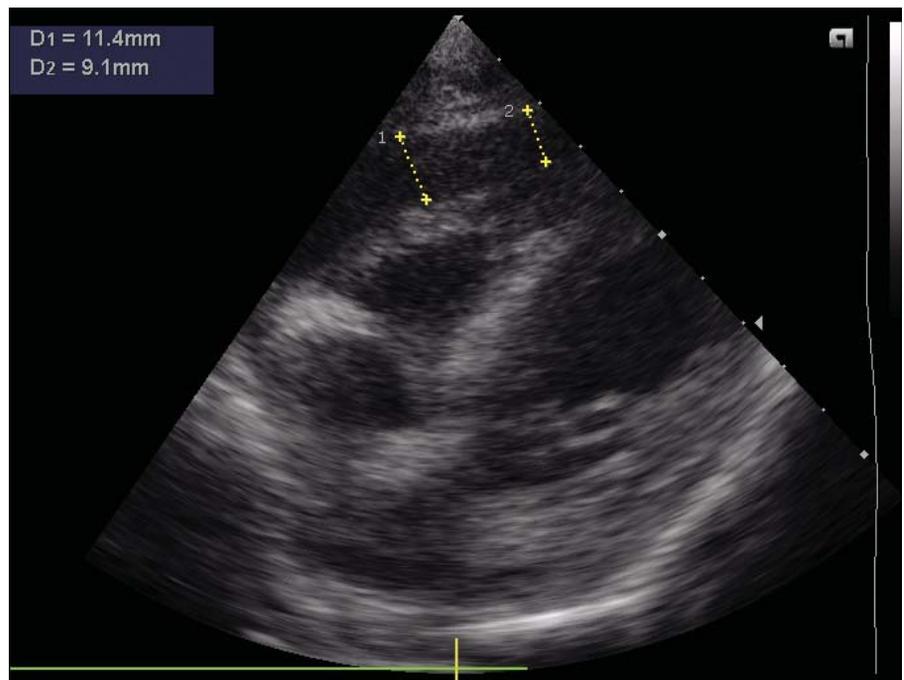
Transthoracic echocardiography, subcostal view. Pericardial effusion with a maximum of 11.4 mm.
